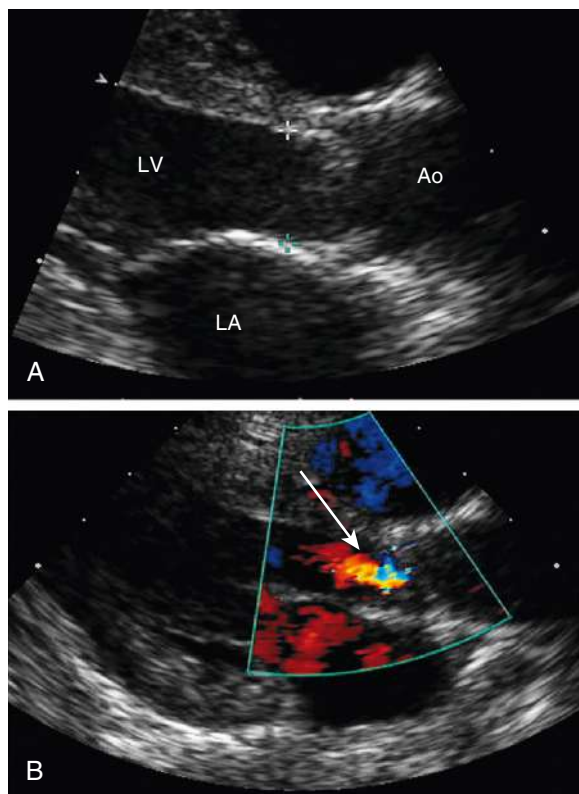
Echocardiogram showing valvar aortic stenosis with regurgitation. A, In this parasternal long-axis view, the stenotic aortic valve can be seen doming in systole. The crosshatch marks delineate the aortic annulus. B, Doppler study shows the presence of aortic regurgitation (arrow). Ao, Aorta; LA, left atrium; LV, left ventricle.
